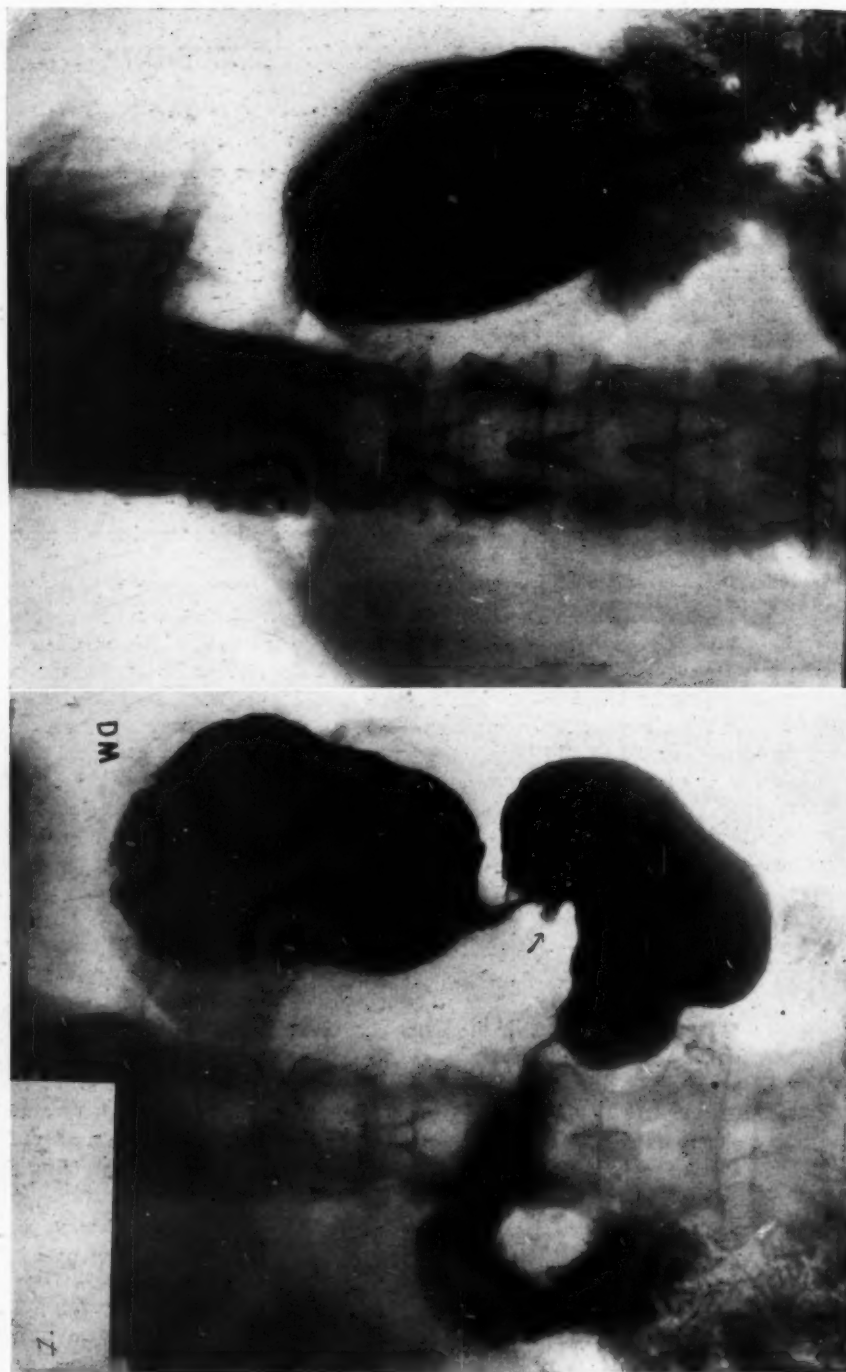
Reproduction of roentgenogram with barium meal ten months after operation.
